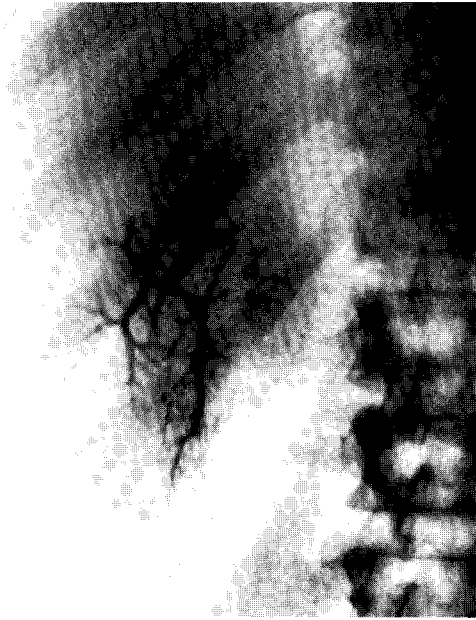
Plain x-ray of the abdomen showing oil embolization in the portal venous radicles of the left lobe.
